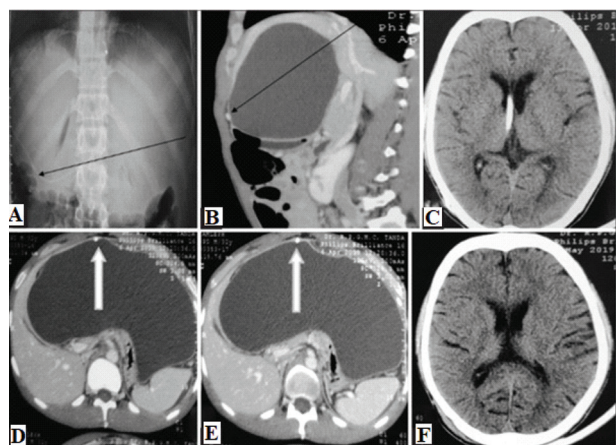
(A) An X-ray showing the abdominal end of the shunt (black arrow) in the location of pseudocyst. (B, D, E) non-contrast computed tomography (NCCT) abdomen showing large pseudocyst abdomen with abdominal catheter lying along its anterior wall, as shown by black and bold white arrows. (C) NCCT head showing the ventricular end of the shunt. (E) NCCT head after removal of the shunt with no hydrocephalus. Image credits: Kumar M, et al. *Central dilemma in CSF pseudocyst - A case series and review of literature. J Neurosci Rural Pract.* 2022 Oct-Dec;13(4):753-758. doi: 10.25259/JNRP-2021-7-25. Reused under the terms of the Creative Commons Attribution-Non-Commercial-Share Alike 4.0 License
